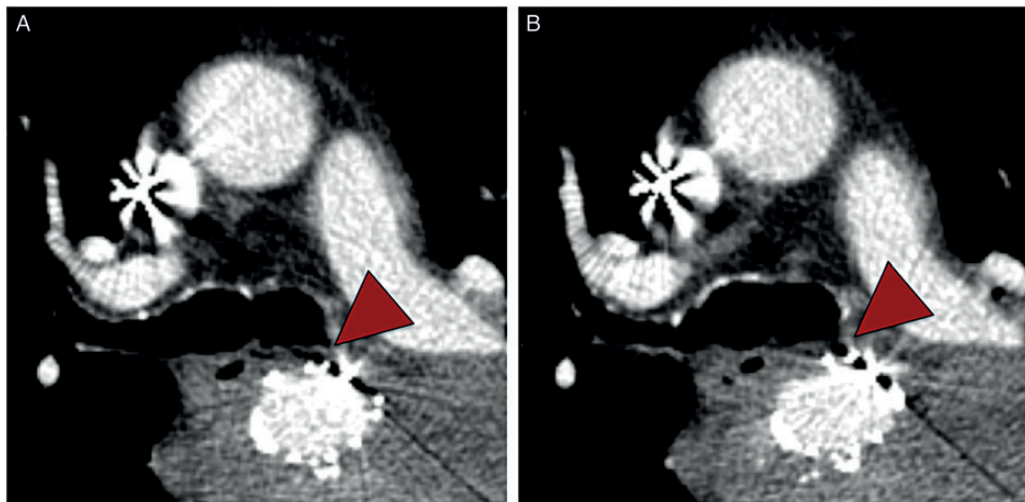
Computed tomography of the chest showing an aorto-bronchial fistula with a communication between the left main bronchus and the stent graft at the level of the descending aorta (dark red arrow heads; A and B).
